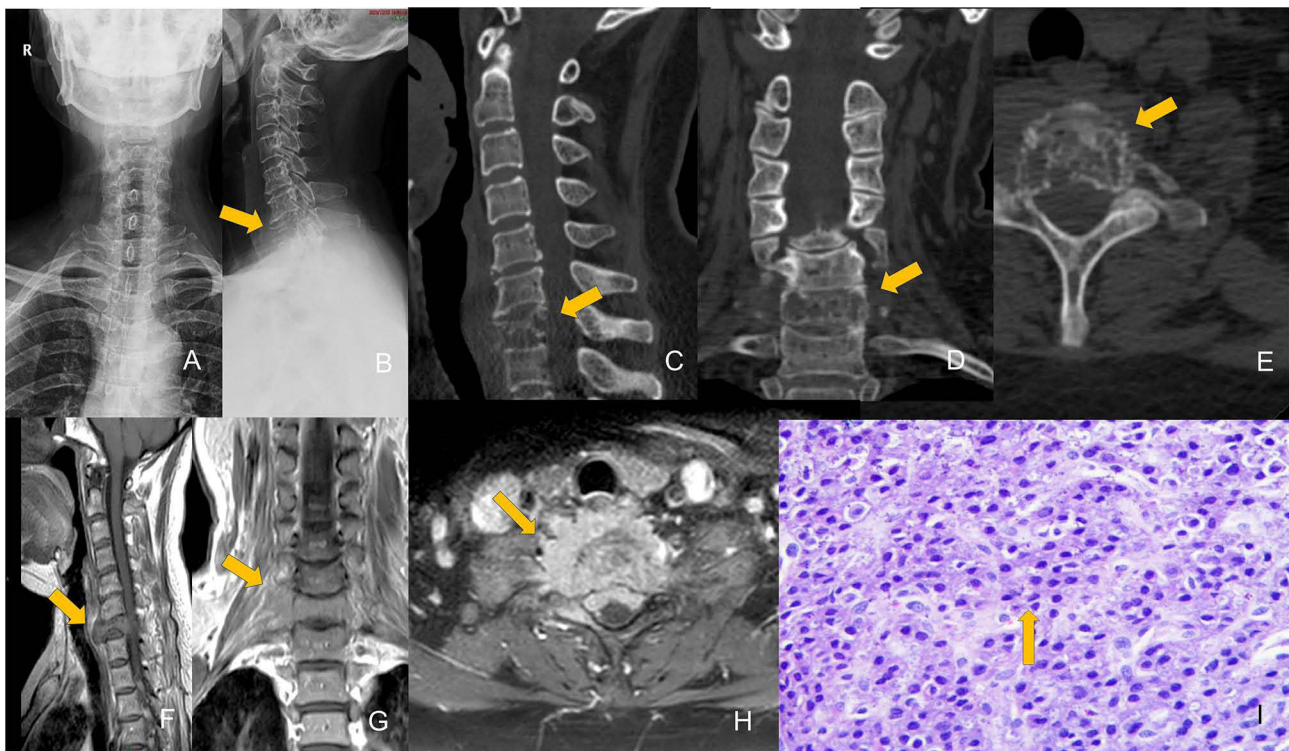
Solitary Plasmacytoma of the C7 Vertebral Body, Female, 55 years old, with right upper limb pain and numbness for half a year. (A and B) Radiographs show pathological fracture of the C7 vertebral body. (C–E) CT scan without contrast shows lytic bone destruction of the lesion with pathological fracture. (F and G) Contrast-enhanced T1WI in sagittal and coronal views shows moderate enhancement of the lesion. (H) Contrast-enhanced fat-suppressed T1WI axial view shows more pronounced enhancement of the lesion. (I) HE ($\times 20$) shows that multiple small round blue cells (arrow).
